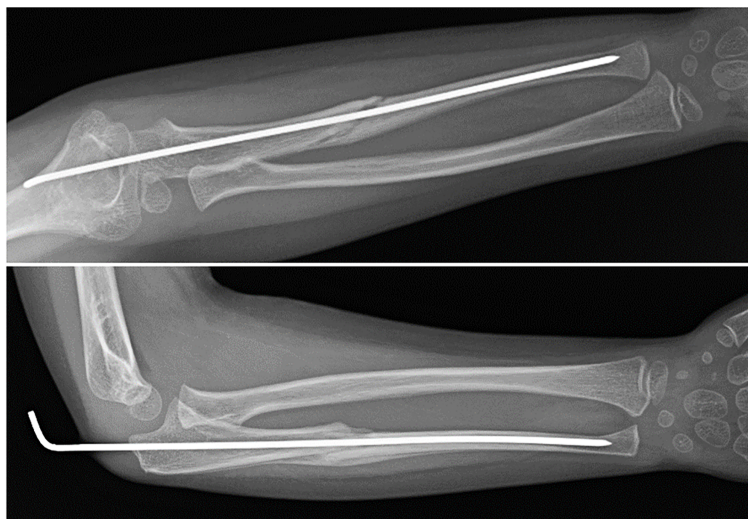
Radiographs at six weeks of follow-up showing reduction of the radial head dislocation and adequate healing of the proximal ulna fracture.
